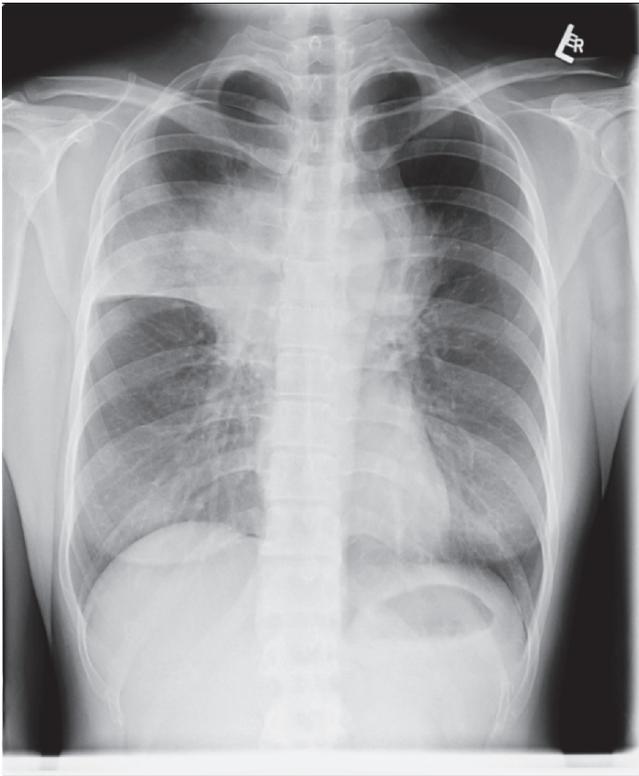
(A) Chest X-ray of a patient with a bulky anterior mediastinal mass; (B) CT scan of a patient with a bulky anterior mediastinal mass.
